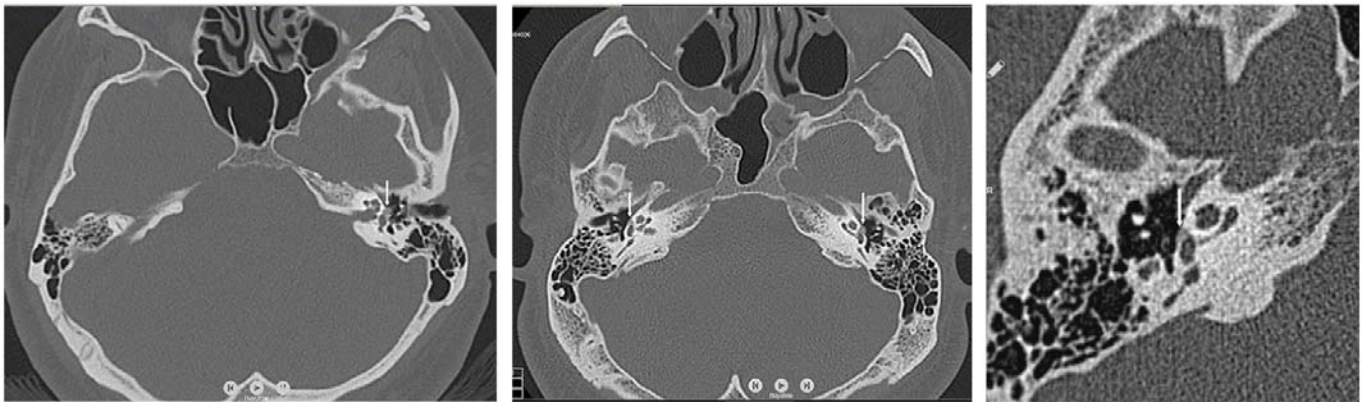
Otosclerotic foci in different temporal HRCT images; white arrows show the foci
